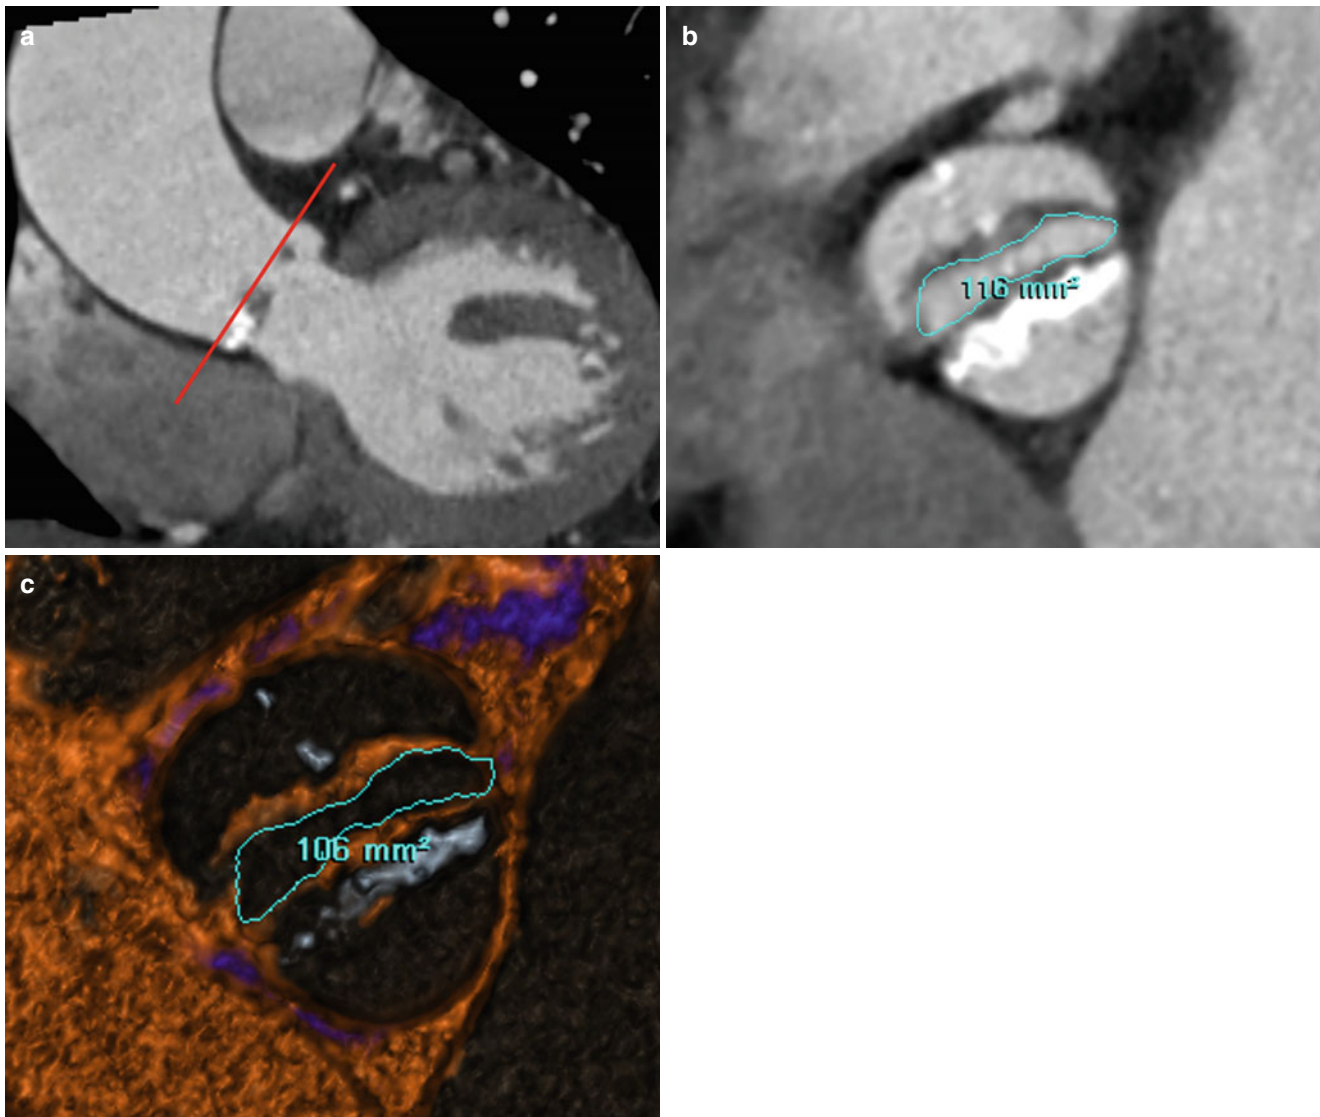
Example of measurement of AVA in patient with BAV stenosis. (a, b) Oblique coronal (a) image of CT demonstrates that measurement of the AVA in the plane described by the borders of the aortic cusps (red line). AVAs by planimetry are 1.16 and 1.06 cm² on CT
